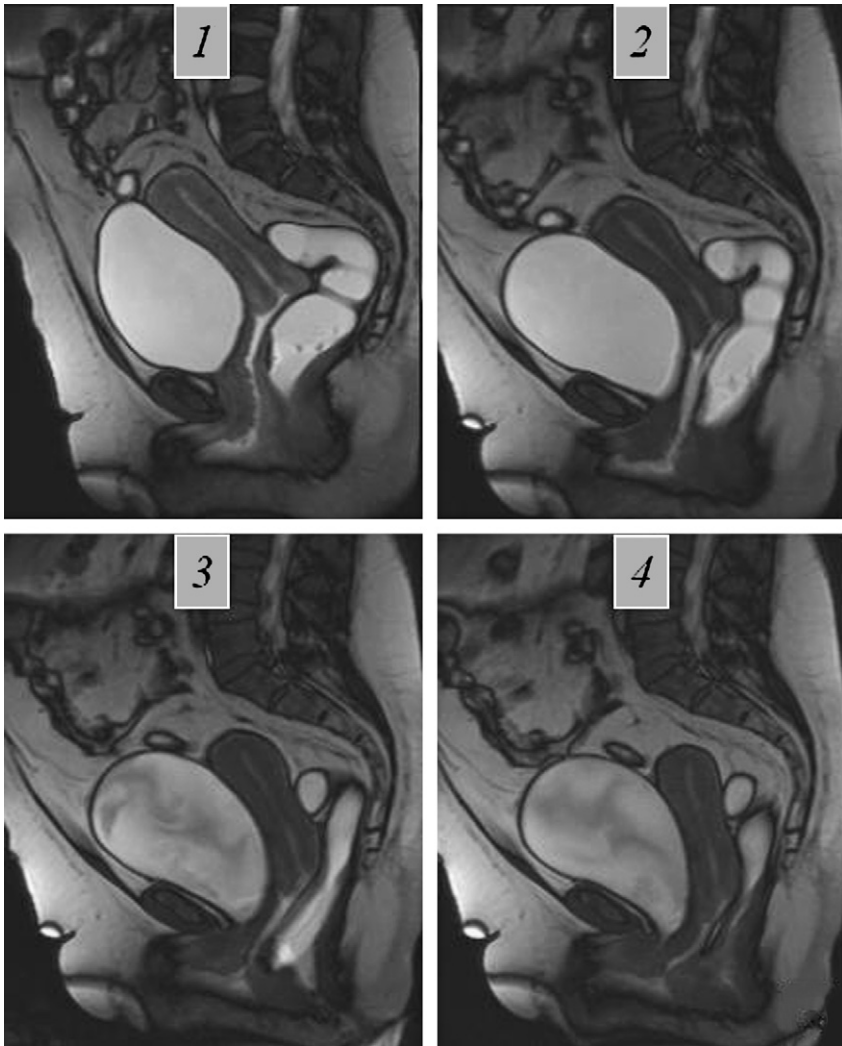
Dynamic MRI defecography. Four dynamic consecutive images taken in the same woman during rectal evacuation: (1) squeeze, (2) anal sphincter opening, (3 and 4) rectal emptying.
